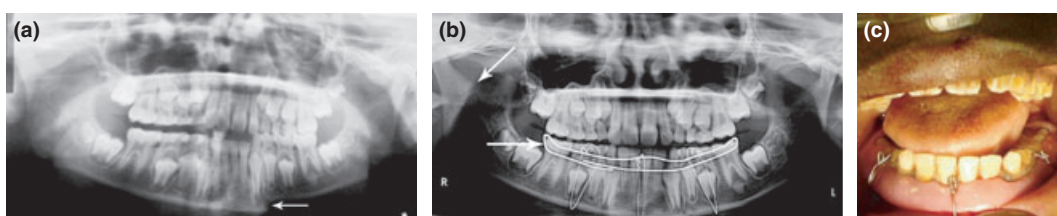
(a) Preoperative orthopantomogram (OPG) revealing parasymphysis fracture. (b) OPG revealing right subcondylar fracture and splint reinforced with wire. (c) Open cap splint *in situ*.
